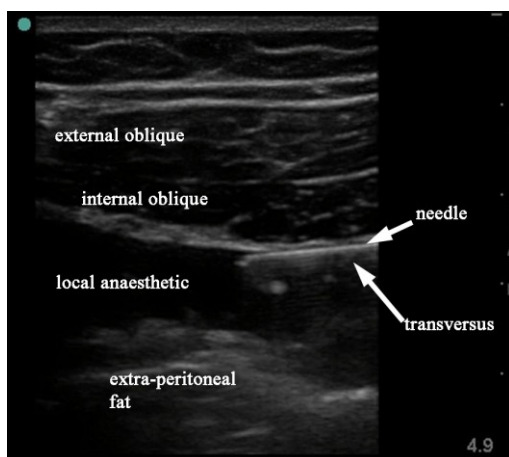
sonogram at the conclusion of the TFP block
